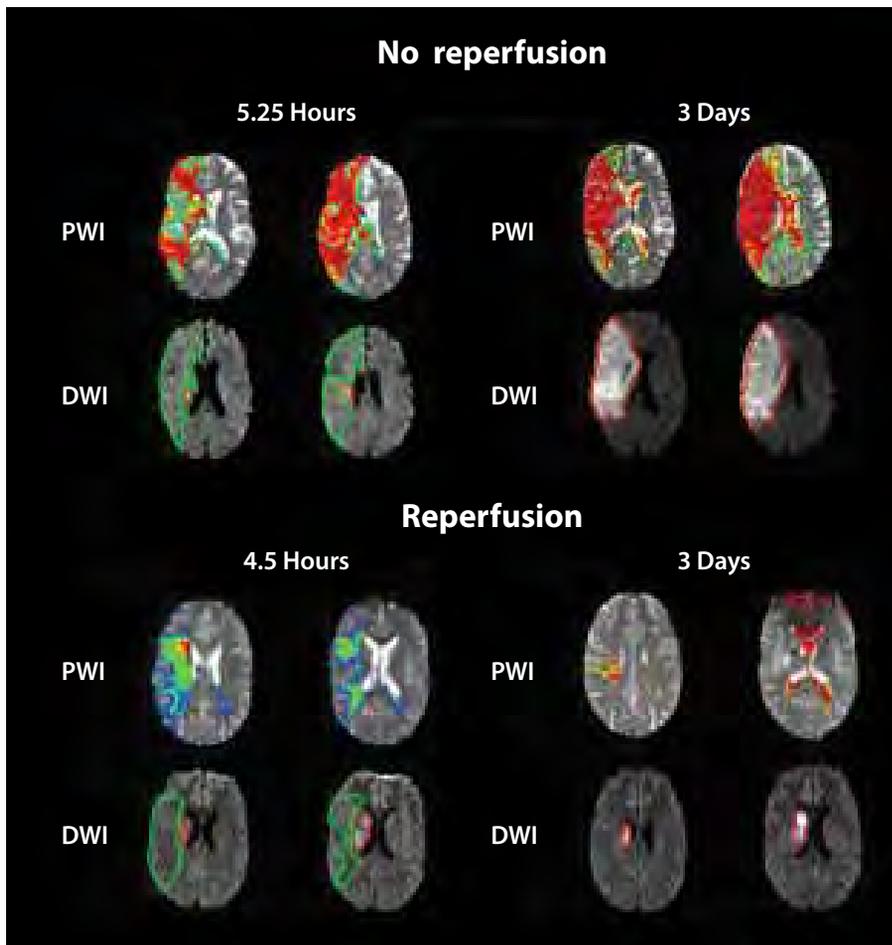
Changes over time in penumbra size, with and without reperfusion, determined by perfusion-weighted and diffusion-weighted image (PWI/DWI) mismatch. Figure courtesy of Osama Zaidat, MD.
